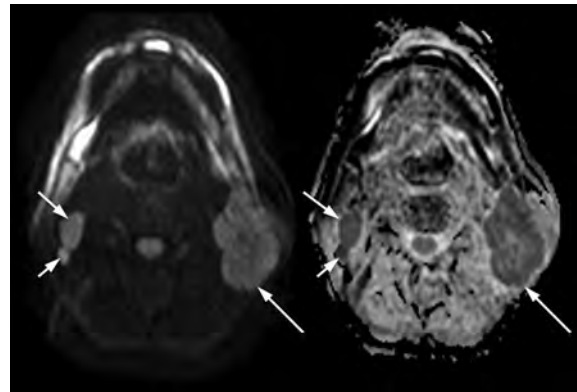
Axial DWI-MRI diffusion image at b1000 (left) with corresponding ADC map (right) in a patient with HNSCC. Metastatic right level II nodes (short arrows) and a left level II nodal mass (long arrow) have a mean ADC of 0.94 and $1.04 \times 10^{-3} \text{ mm}^2/\text{s}$ respectively. These values are comparatively low, signifying restricted diffusion, which is compatible with malignant infiltration
